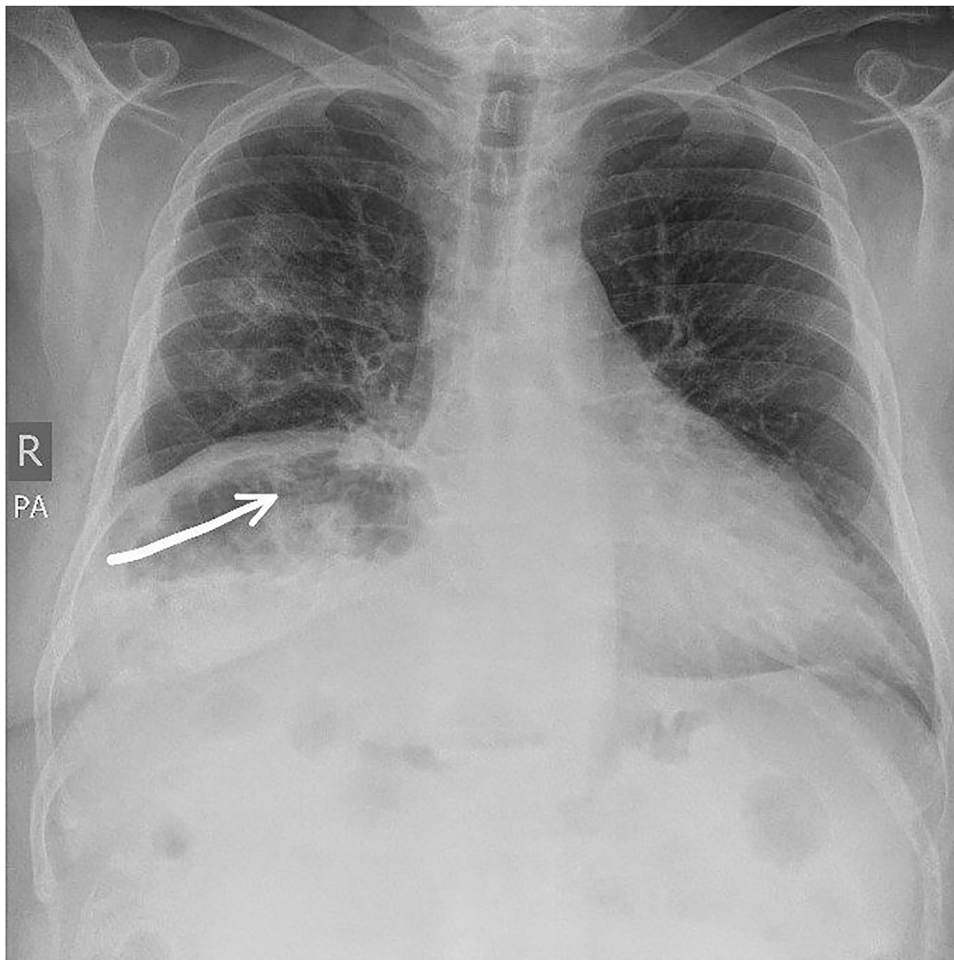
Chest X-ray showing air under the right copula of the right diaphragm.
